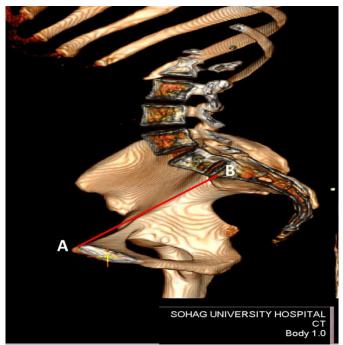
An Image of pelvic 3D volume rendered reconstruction of CT scan; anatomical conjugate diameter extending between symphysis pubis upper border (A) and the sacral promontory tip (B).
